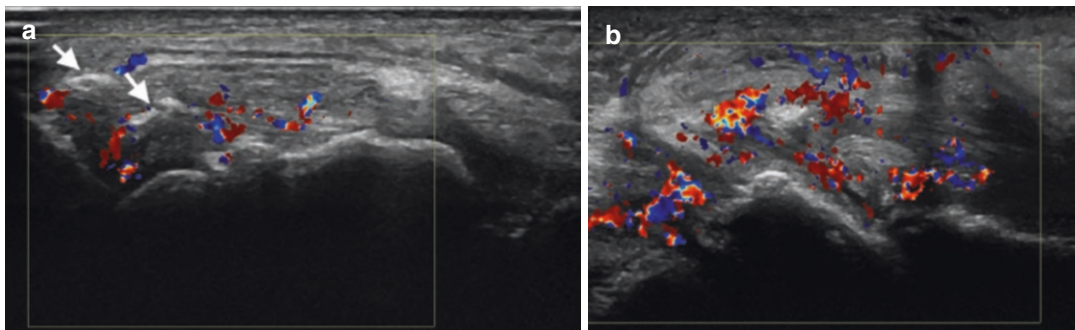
Ultrasound of Charcot ankle joint demonstrating (a) increased internal flow on colour Doppler in keeping with active synovitis surrounding echogenic internal
